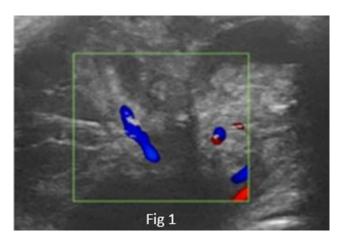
Ultrasonography of right parotid region shows diffusely heterogeneous solid cystic lesion in the superficial lobe of right parotid gland with prominent vascularity
